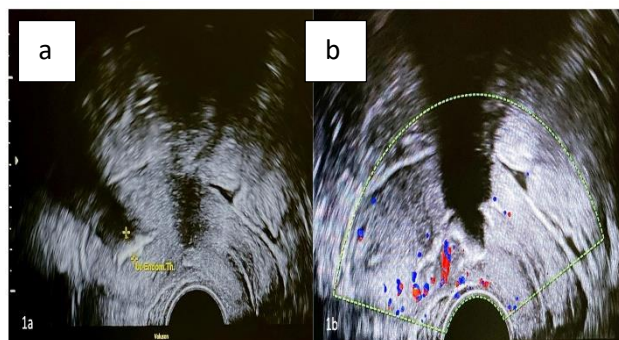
a) Demonstrating ultrasonographic picture of hyper echoic endometrium suggestive of calcification with posterior acoustic shadowing, b) corresponding doppler image for the same patient demonstrating no vascularity.
